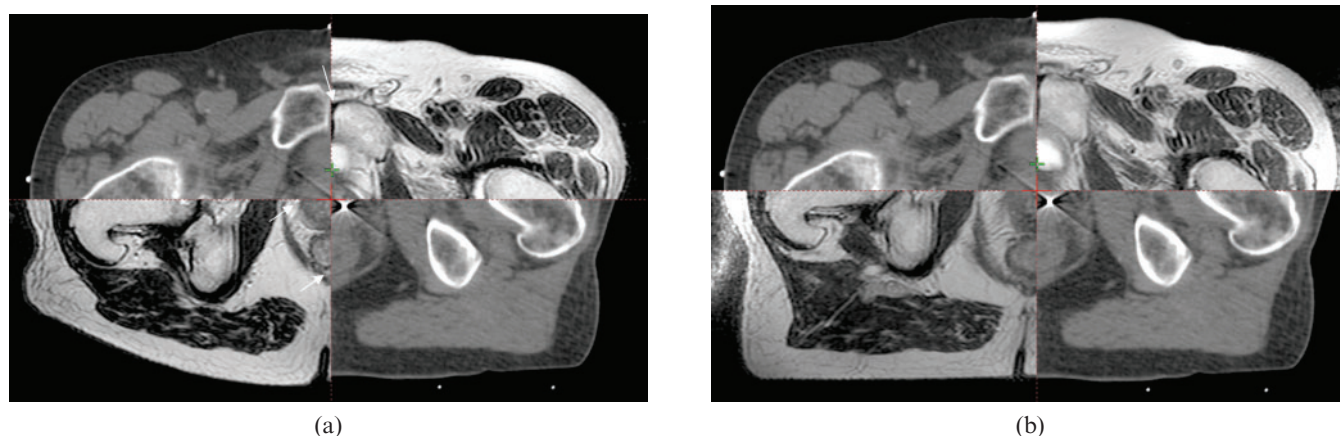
Split view showing the registration of (a) the CT and MRI_D and (b) the CT and MRI_{RT} data sets. White arrows on image (a) indicate errors in registration which can be seen to be corrected on (b). MRI_D, diagnostic MRI scan; MRI_{RT}, MRI scan in the radiotherapy position.
